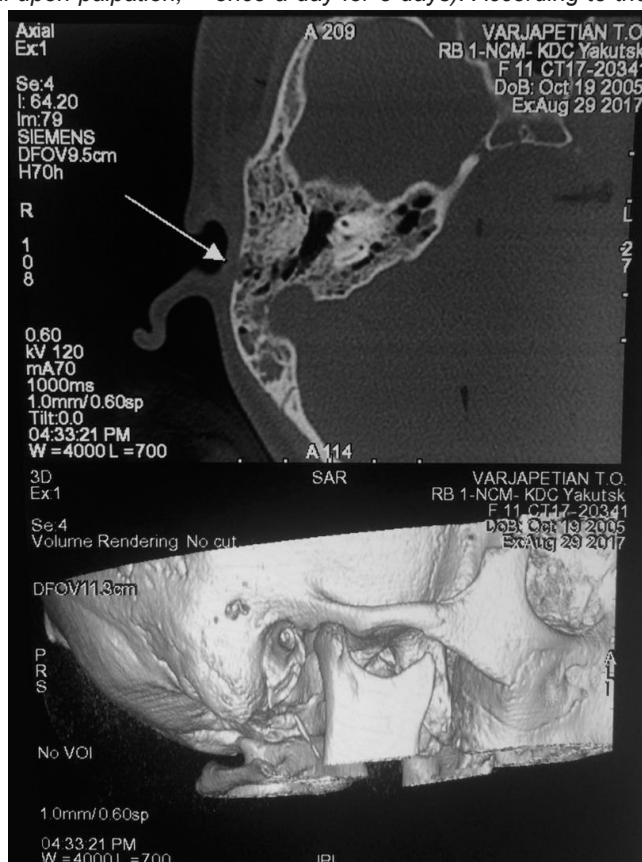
CT-picture of destruction of the cortical layer of the mastoid process.
